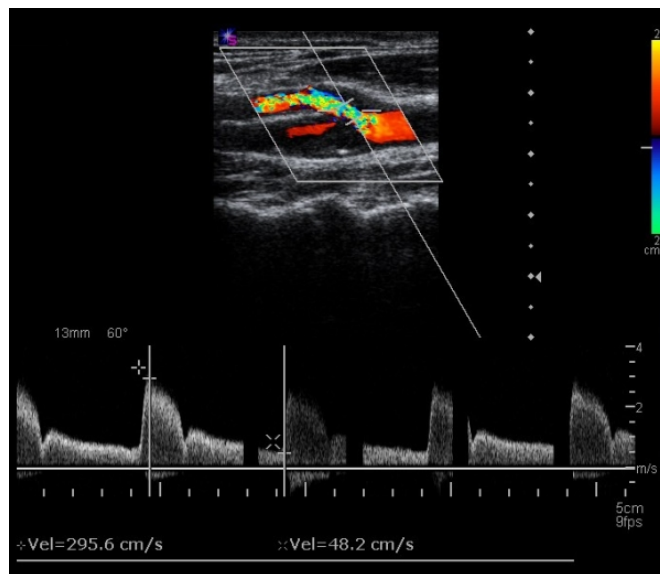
Duplex ultrasound: the small, combined B-mode and CFI display is used to guide the positioning of the spectral Doppler sample volume.
